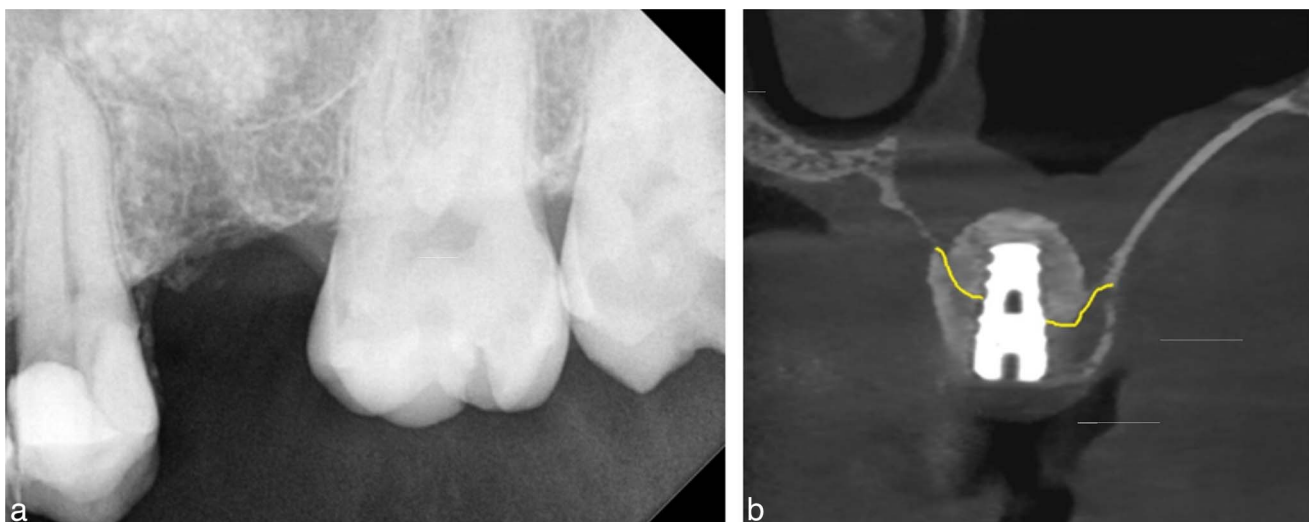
Radiograph at 4 months post sinus elevation (a) and cone beam computerized tomography cross-section following implant placement (b) (yellow line indicating pretreatment sinus floor position).
